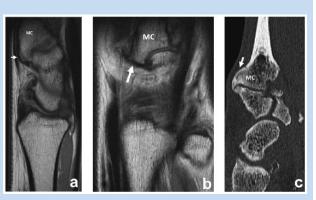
(a) Sagittal and (b) coronal magnetic resonance images of the wrist demonstrating a carpal boss (arrows) with medullary continuity with the base of the second metacarpal in a 40-year-old man who was asymptomatic with regard to his os styloideum. (c) Sagittal reformatted computed tomography image of the wrist demonstrates the appearance of a large carpal boss with osseous remodeling. MC, metacarpal.
